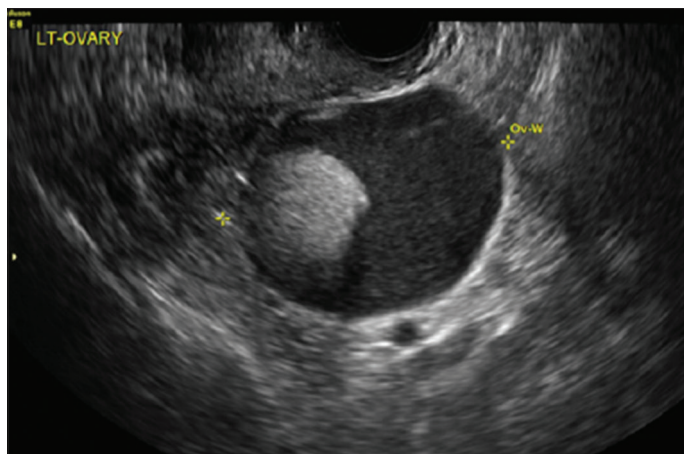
Ultrasonogram image of left ovarian cyst
